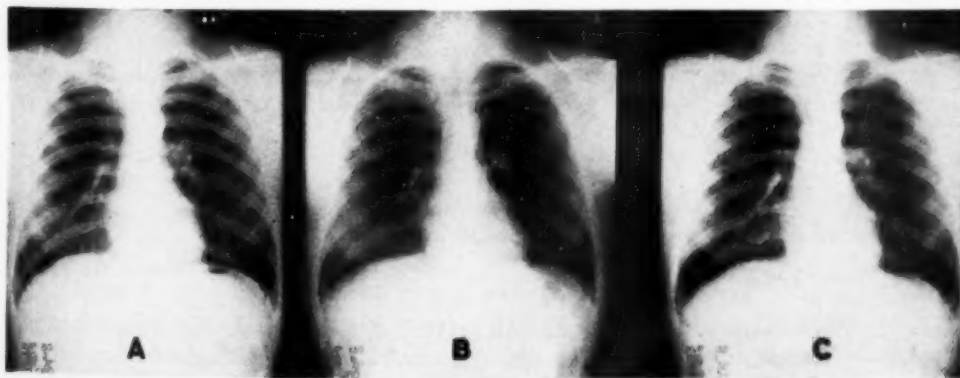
Postero-anterior radiographs of chest. A. 80 kv.p., 3 ma., 72 in. distance, no grid. B. 130 kv.p., 1 1/2 ma., distance 72 in., no grid. C. 130 kv.p., 1 ma., 72 in., 5:1 grid.
